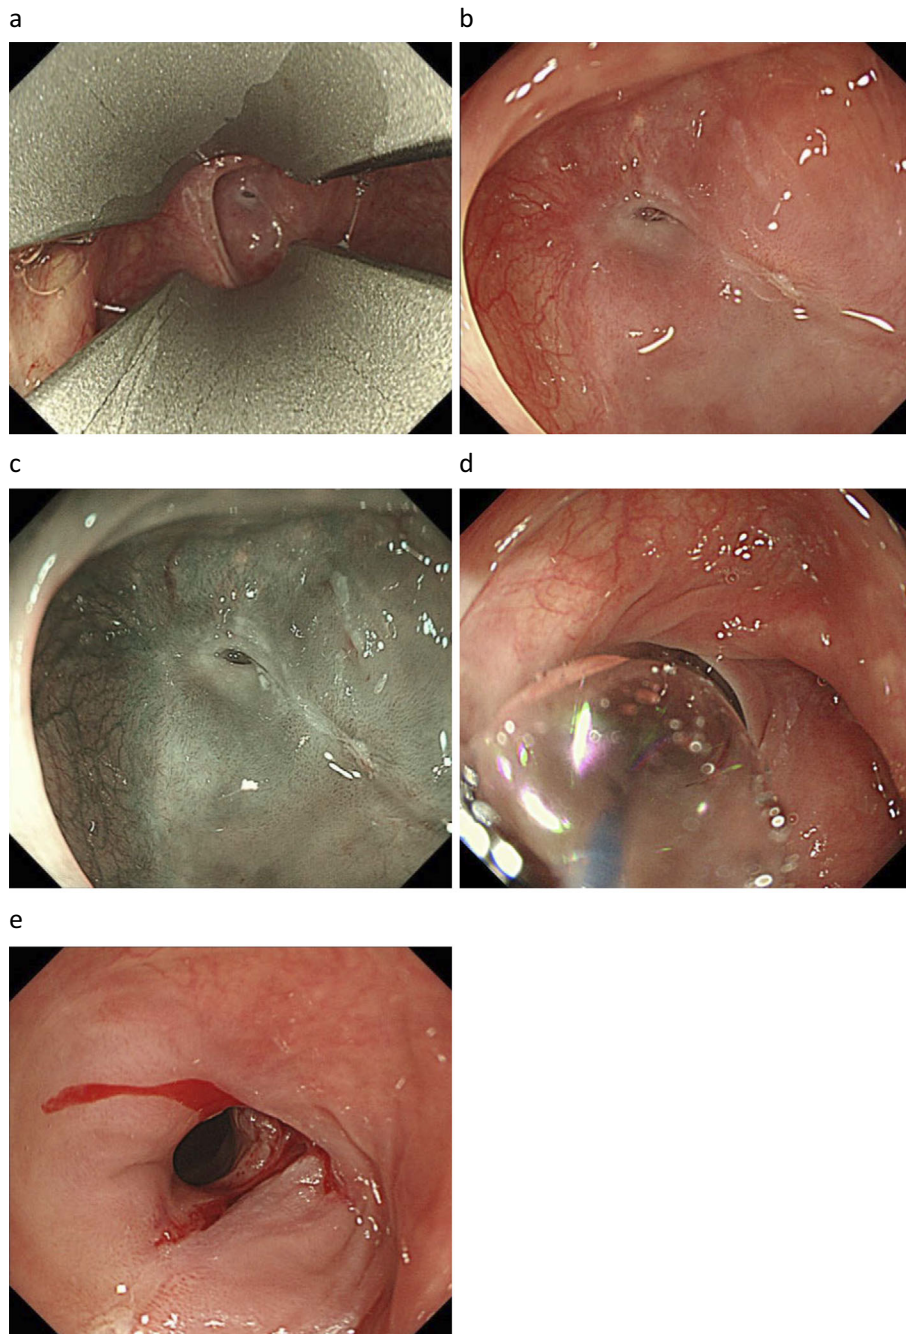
(a) The endoscopic view obtained with a WEERDA distending diverticuloscope. The pyriform sinus and cervical esophageal constriction were observed in detail. (b) Severe stenosis was clearly visualized just beyond the esophageal entrance, and an oblique linear scar was found on the posterior side of the stenotic lesion. (c) Image-enhanced endoscopy showed no findings that were indicative of malignancy. (d) The endoscopic view during balloon dilation. The dilation procedure (from 6 mm to 12 mm) was performed under radiography using a CRE balloon dilatation catheter. (e) The endoscopic view after balloon dilation. This treatment was completed without any complications.
